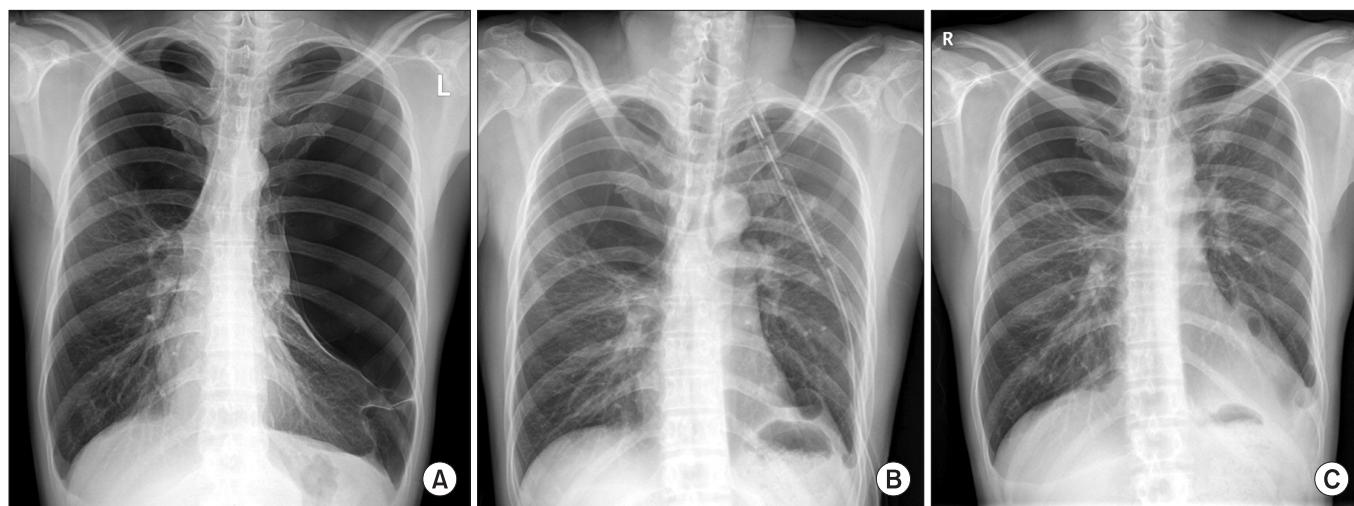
Representative chest radiographies. (A) Bilateral giant bullae occupying almost the entire left hemithorax and a third of the right thorax; preoperative period. (B) Postoperative period. (C) Follow-up 1 month after surgery.
